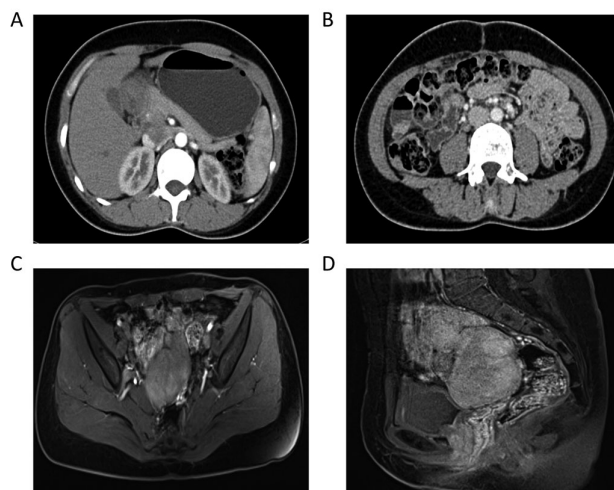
CT and MRI view of case 4. (A) Transverse view of CT of the upper abdomen before treatment. (B) Transverse view of CT of the middle abdomen before treatment. (C) Transverse view of MRI of the pelvic cavity before treatment. (D) Sagittal view of MRI for the pelvic cavity before treatment.
